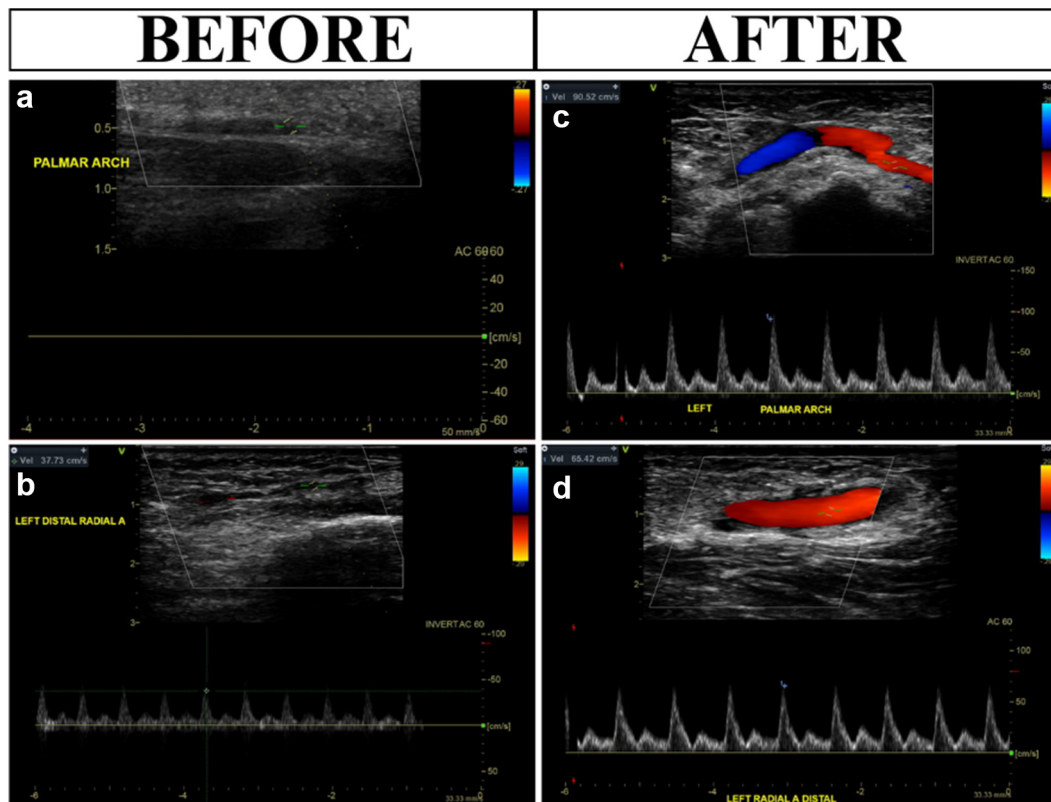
Duplex ultrasound waveforms before intervention of the palmar arch (a) and radial artery (b) compared with waveforms after intervention for the palmar arch (c) and radial artery (d).
